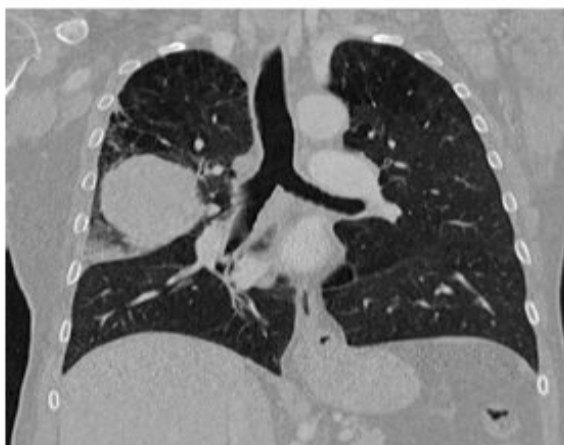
Chest CT, sagittal plane showing the craniocaudal extension of the tumor in the right upper lobe.
